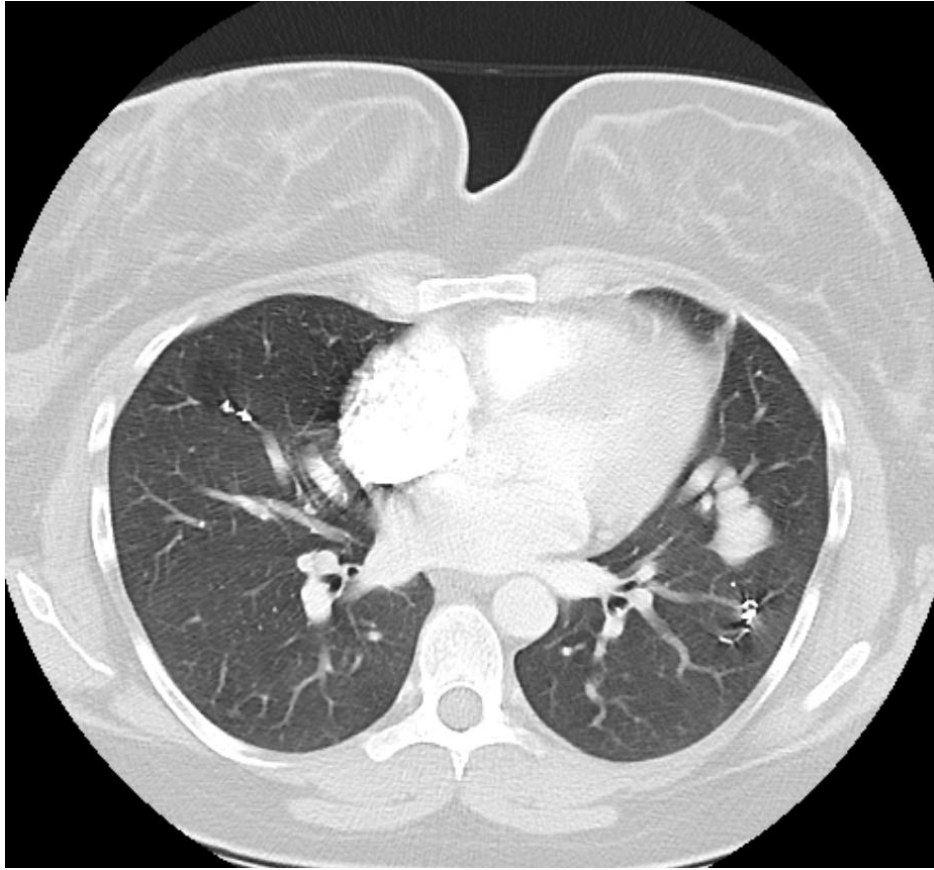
Computed tomography scan following coil placement following acute PAVM rupture in the postpartum period.
